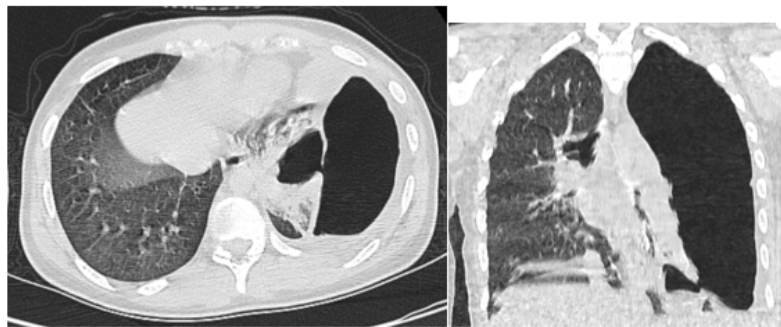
Axial and coronal pulmonary CT scan sections showing a left, oval intraparenchymal cystic formation, containing a hydro-aeric level, with a defect in its wall communicating with the pleura and responsible for a large hydropneumothorax collapsing the ipsilateral lung. Pulmonary hydatid cyst ruptured in the pleura and bronchi in 13-old-child.
